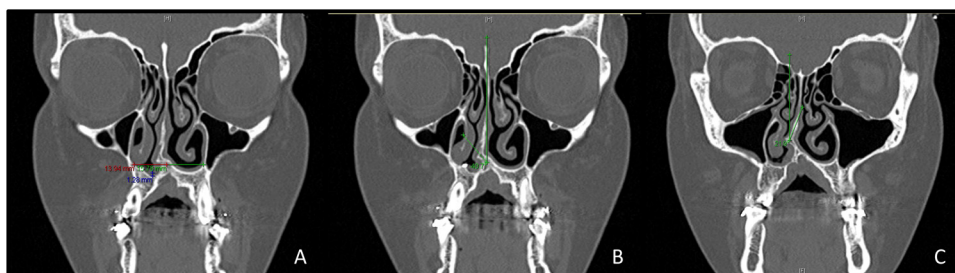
Cone beam computed tomography (CBCT) angle and distance measures from 2D frontal cut. A. In red, the cleft nasal fossa width, in green: the unleft nasal fossa width, in blue: the height delta between the two nasal fossa. B. Angle deviation between the median vertical and the bony septum. C. Angle deviation between the median vertical and the cartilaginous septum.
